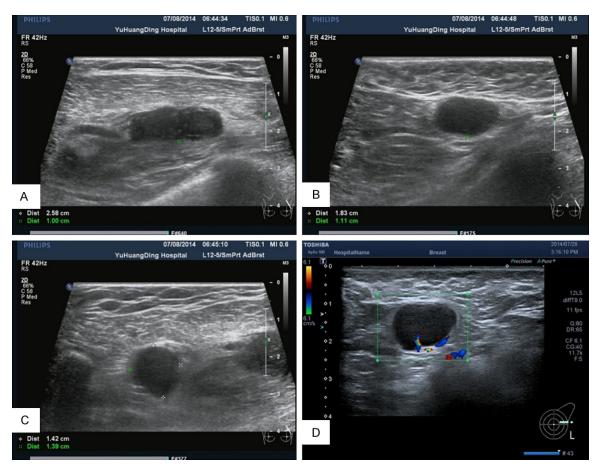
B-ultrasound imaging of the left breast masses. A-C. Three nodules in the left breast. D. Axillary nodule. Colored areas reflected blood flow.
